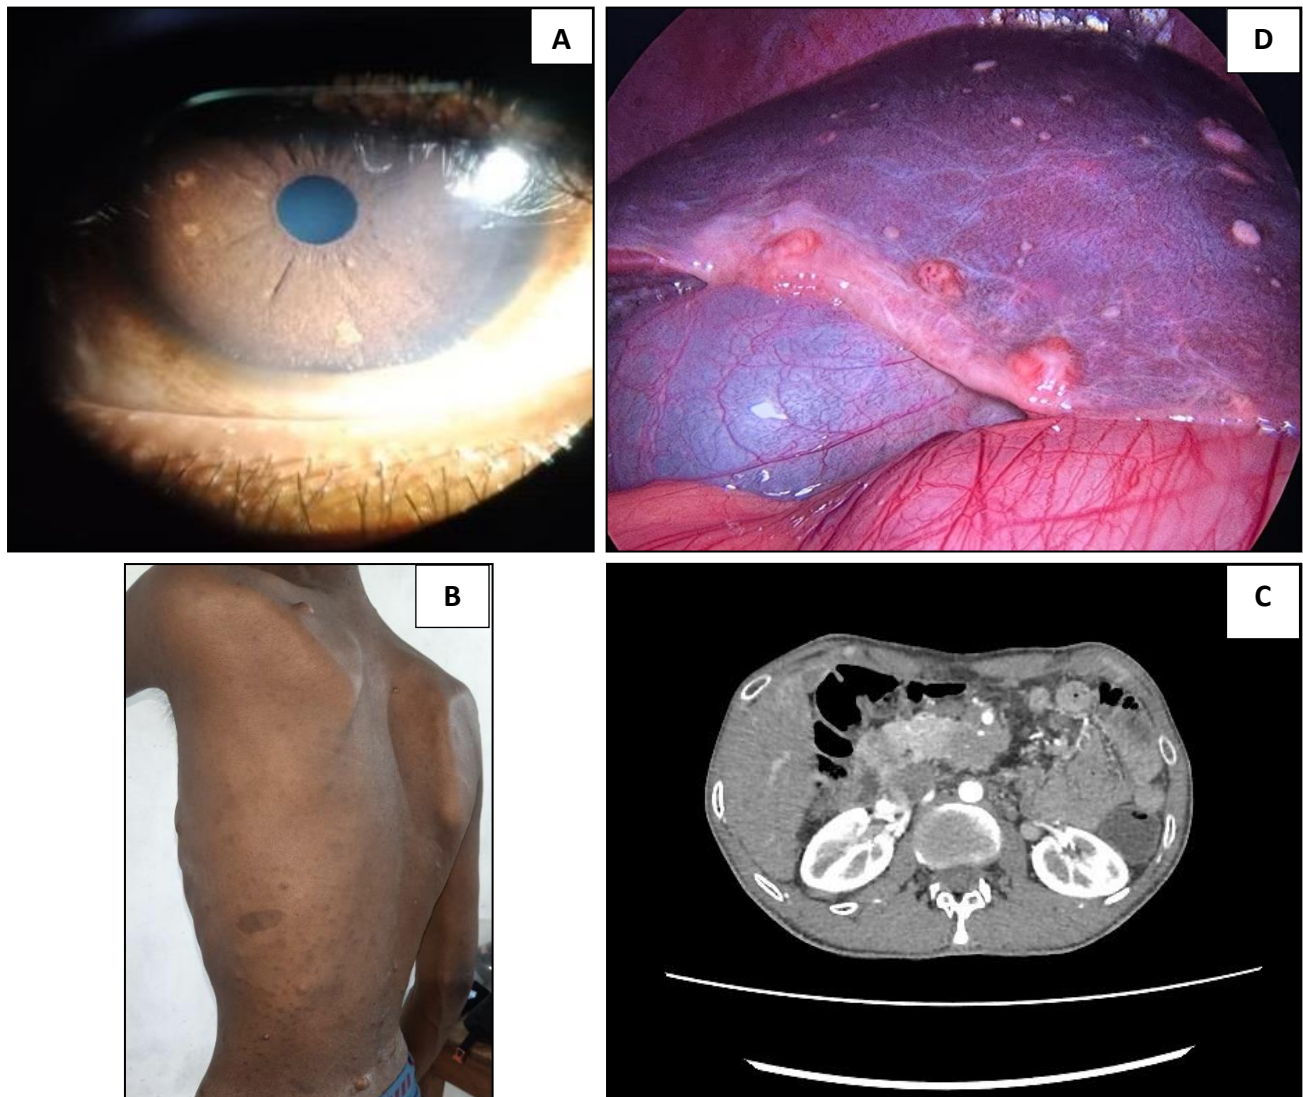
Photographs of the proband showing A) Lisch nodules; B) Café-au-lait macules and cutaneous fibromas on the back of the trunk; C) Contrast-enhanced computed tomography scan of the abdomen showing retro-pancreatic mass with encasement of superior mesenteric artery; D) Laparoscopic view of multiple liver metastasis
